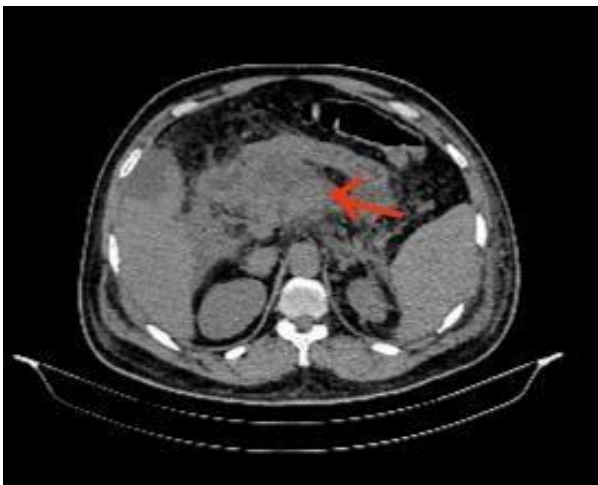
Contrast enhanced CT scan of abdomen (axial view) showing decreased enhancement (arrow mark) in the neck/body of the pancreas suggestive of necrotizing pancreatitis.
